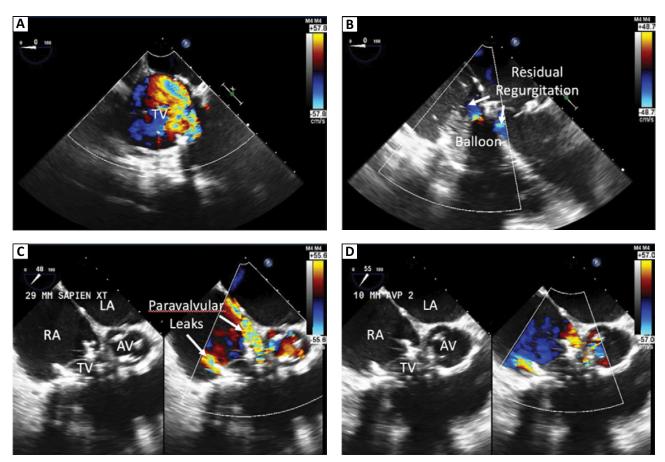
Transesophageal Doppler echocardiographic images. *Panel A.* Tricuspid valve color Doppler pre-deployment demonstrating severe regurgitation. *Panel B.* Balloon inflation across the native valve demonstrated residual medial regurgitation in the open part of the annuloplasty ring. *Panel C.* Post-deployment of a 29-mm Sapien XT valve showed moderate medial and mild lateral paravalvular leak (PVL). *Panel D.* Post-deployment of Amplatzer vascular plugs medially resulted in a reduction of PVL. No central regurgitation was noted. RA = right atrium; LA = left atrium; TV = tricuspid valve; AV = aortic valve.
